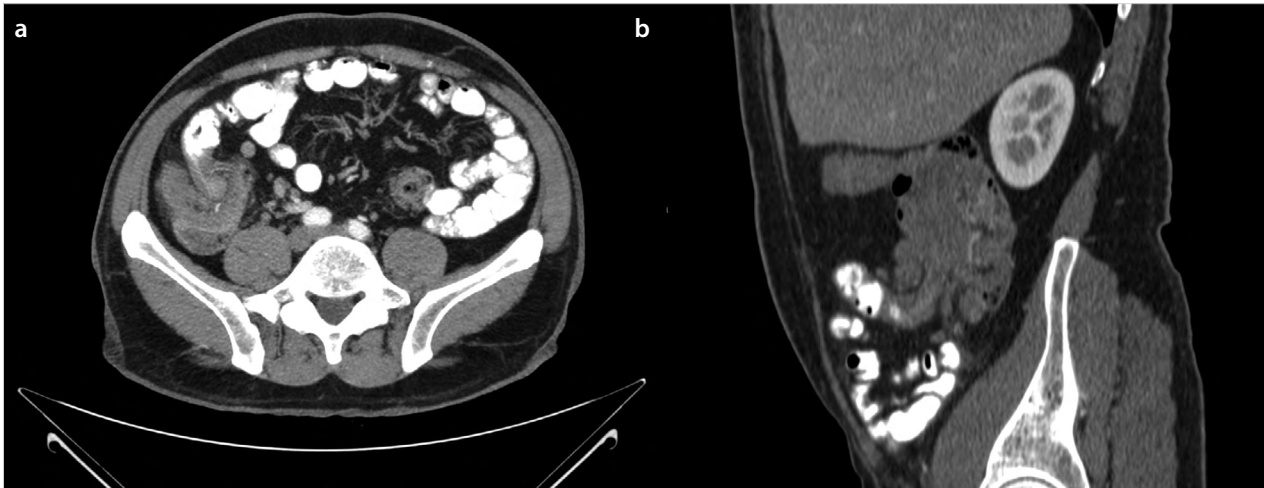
a, b. An ileocecal intussusception on computed tomography examination
